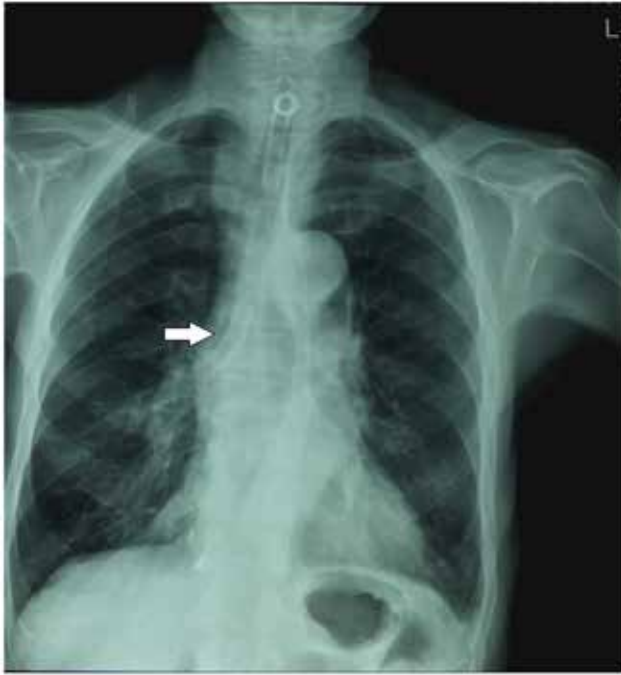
Chest X-ray postero-anterior view showing the fragment of the tracheostomy in the right main bronchus.
